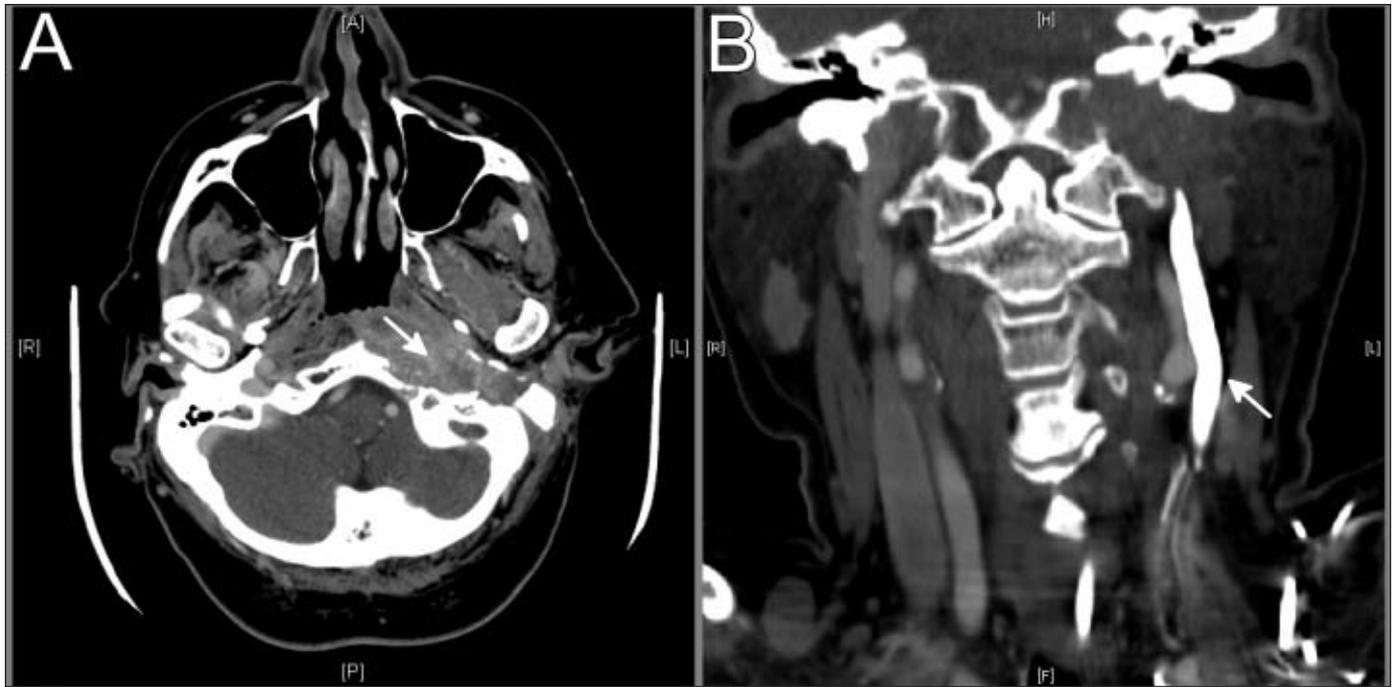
CT head with contrast taken shortly after the onset of cranial nerve IX, X, XI, and XII palsy. A) Contrast-enhanced axial CT shows ill-margined soft tissue (arrow) in the left carotid space that completely surrounds the distal cervical internal carotid artery. B) Contrast-enhanced coronal CT shows erosion of the left clivus and temporal styloid process with deep venous sinus thrombosis (arrow).
